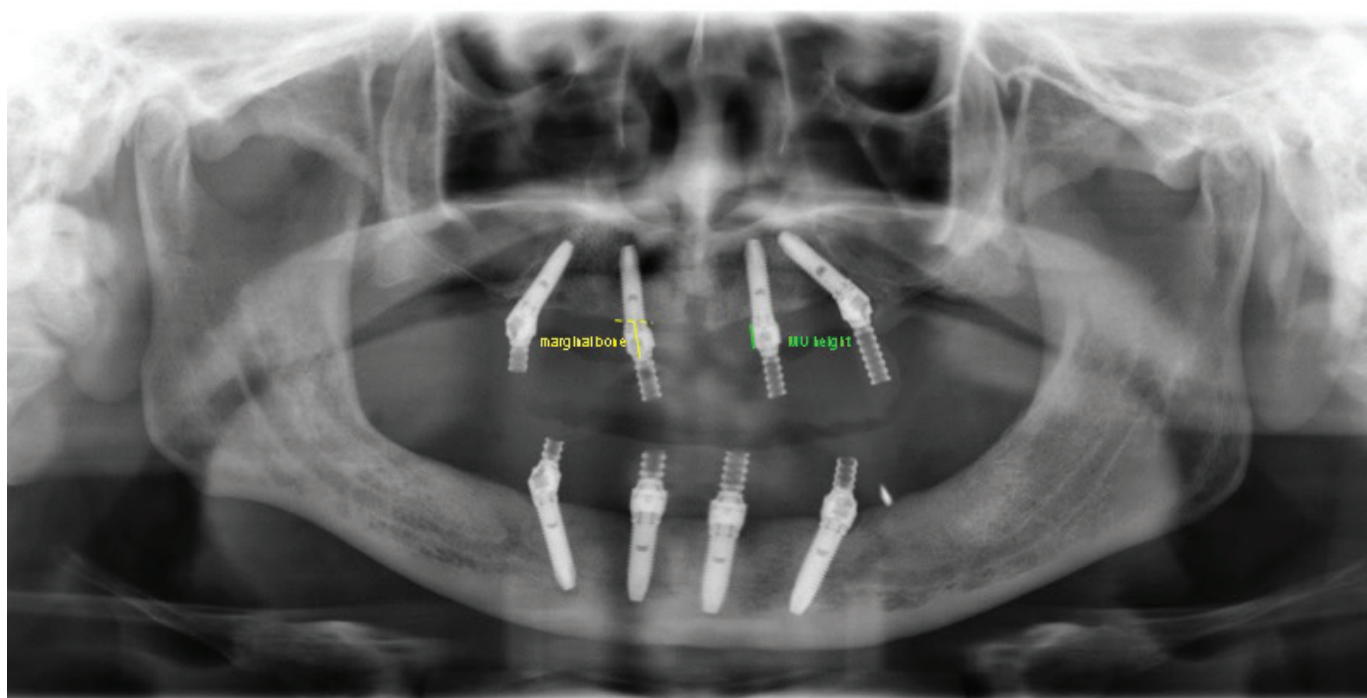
The marginal bone level and MU height were measured from the panoramic image. To compensate for the image distortion of the panoramic radiograph, the marginal bone level was divided by the MU abutment height as a ratio, and the ratio was used with the real MU abutment height to calculated the real marginal bone level. (MU: multi-unit abutment)
